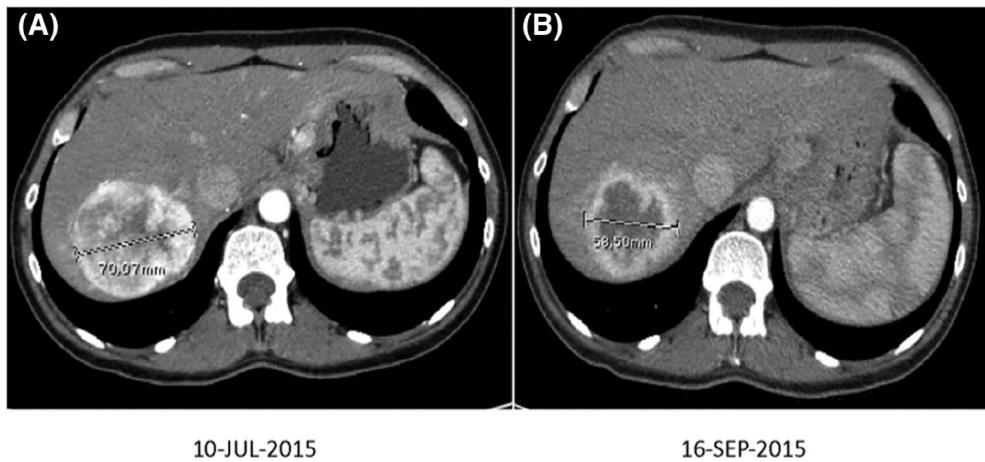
High resolution computed tomography scans from a patient experiencing a partial response at two time points: July 10, 2015 (A) and September 16, 2015 (B). From July 2015 to September 2015, the tumor reduced its total size and increased the necrotic areas present inside. Tumor mass is visible as a clear rounded-shape bulk within the pancreas. Darker areas within the tumor are necrotic regions. Dashed line indicates the maximum tumor diameter used to assess clinical response.
